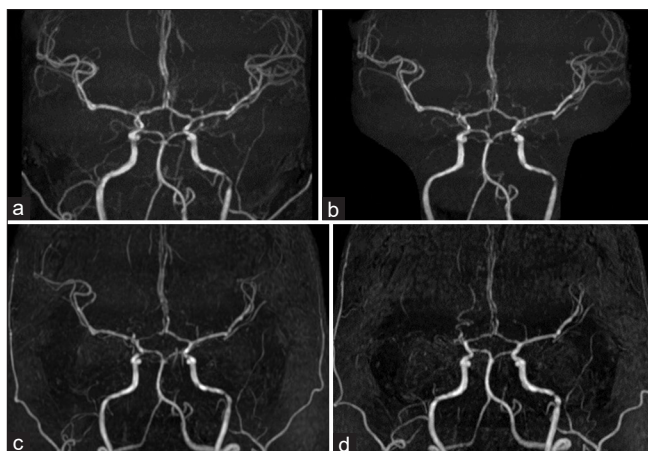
Magnetic resonance image at the age of 41 (a) shows mild stenosis of bilateral middle cerebral arteries (MCAs). At ages 45 (b) and 49 (c), there are no significant changes in the MCAs. At the age of 53 (d), there is an occlusion of the right MCA.
